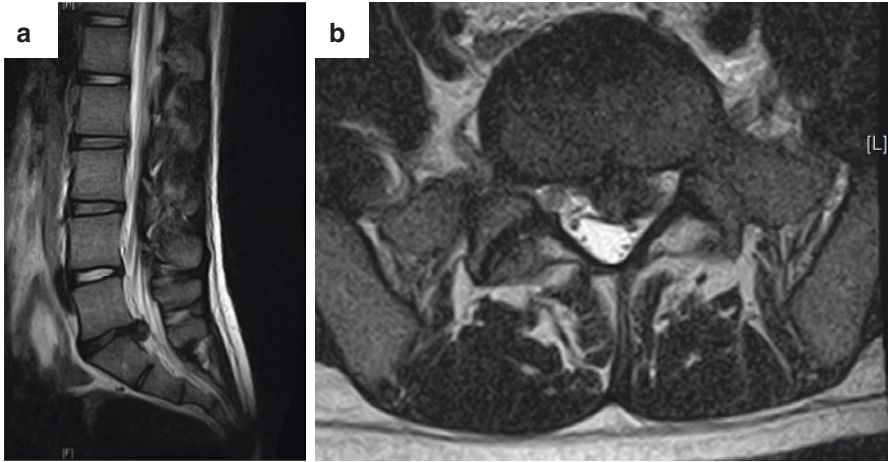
(a) Sagittal T2 MRI lumbar spine demonstrating large disc herniation at L5–S1. (b) Axial T2 MRI demonstrating L5–S1 disc herniation causing lateral recess stenosis causing mass effect on the traversing nerve root without a significant foraminal or extraforaminal component
